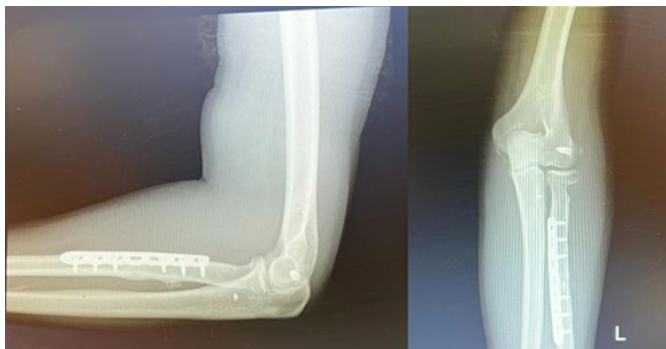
Six months post-operative x-ray control of the left forearm.
